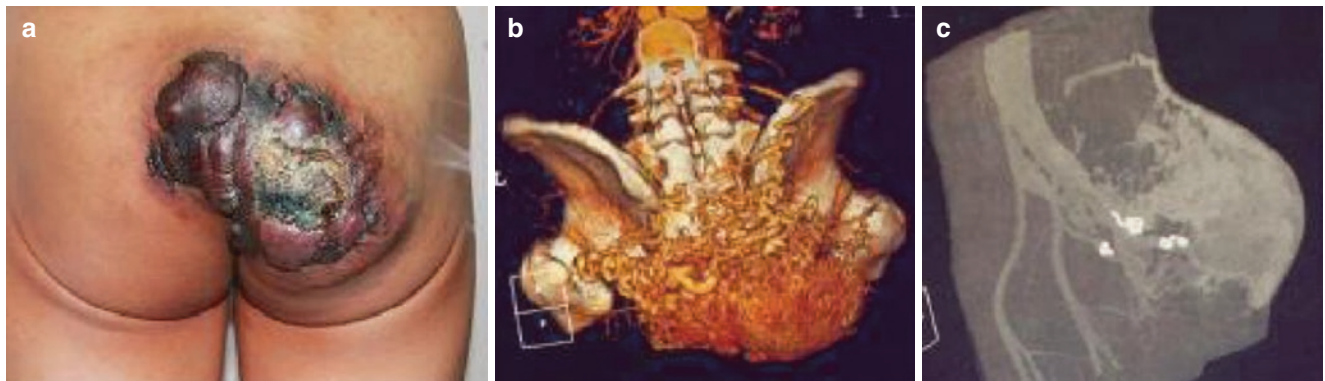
Surgical treatment of hip arteriovenous malformations. (a) Preoperative ulceration and incrustation of hip foci. (b) CTA indicates the relation between the deformed vascular masses and the pelvis. (c) CTA indicates the presence of emboli. (d) CTA indicates the relation between foci and blood-supplying arteries. (e) DSA indicates the presence of a large quantity of arteriovenous fistulous orifice, whose blood
